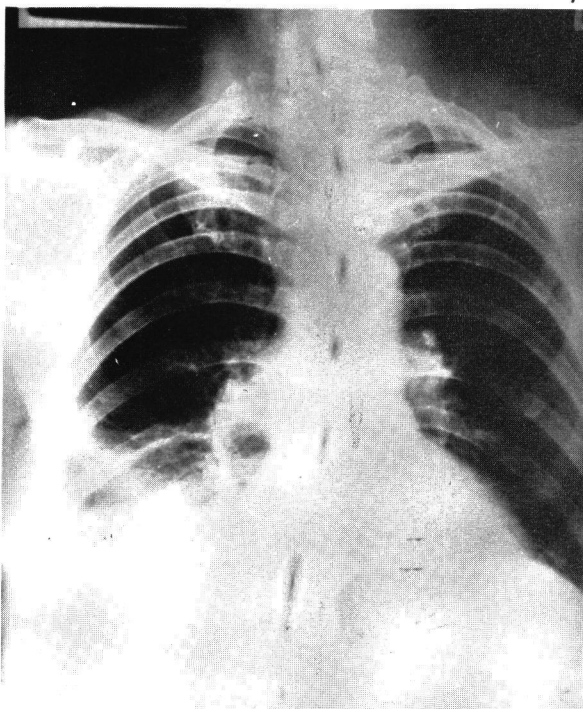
Chest X-ray showing a right-sided pleural effusion.
